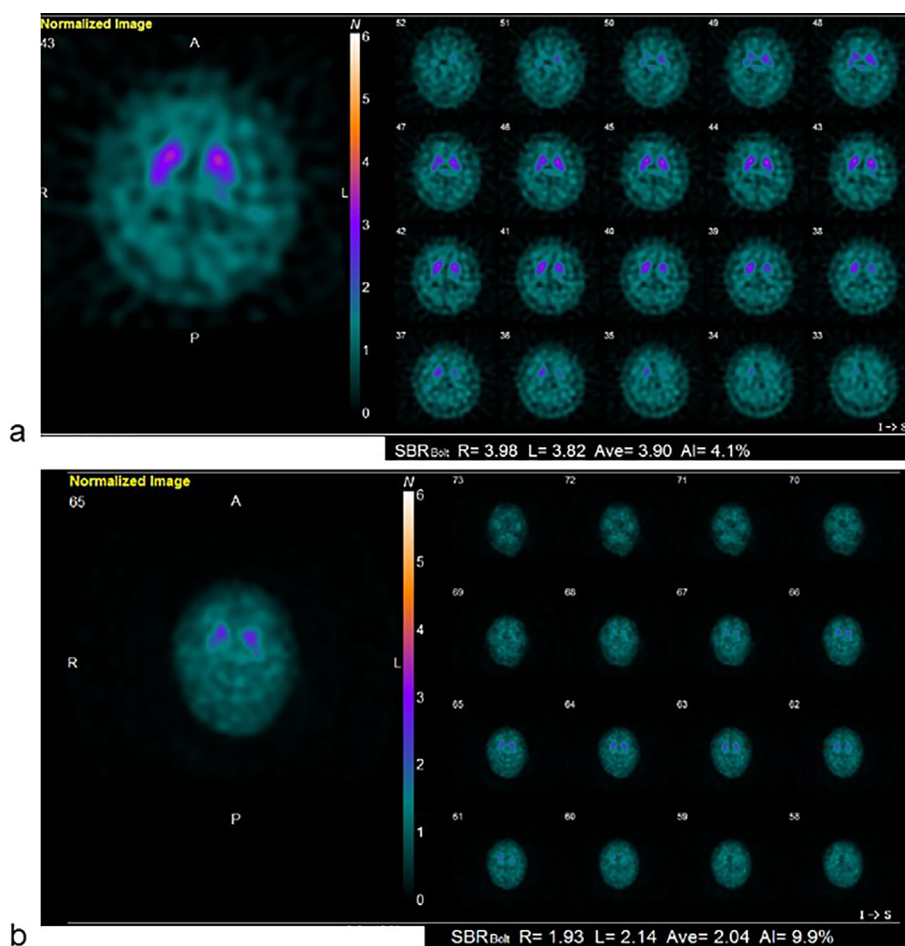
DAT SPECT findings in a case of fatal familial insomnia with parkinsonism. DAT SPECT imaging at (a) 4 and (b) 5 months after the onset of symptoms. The specific binding ratios (SBRs) were right=3.98, left=3.82 in (a) and right=1.93, left=2.14 in (b). An SBRs of 4.5 is the threshold for dysfunction in our institution. DAT SPECT: dopamine transporter single-photon emission computed tomography
